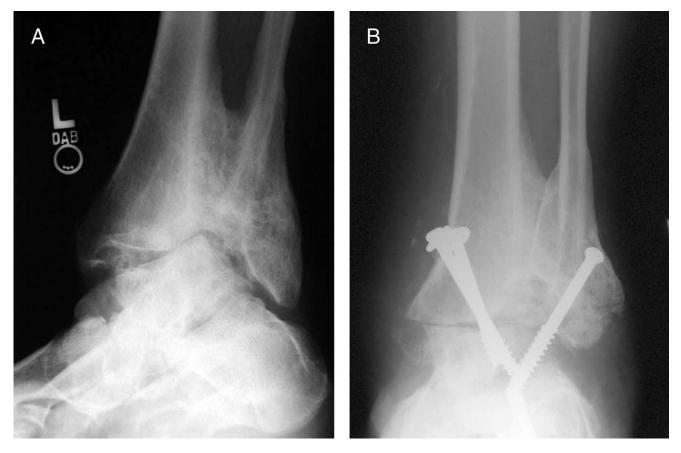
(A) Preoperative mortise radiograph of the patient with the single nonunion in our series. (B) Fifteen-month postoperative radiograph with good correction of position, but a persistent nonunion.
